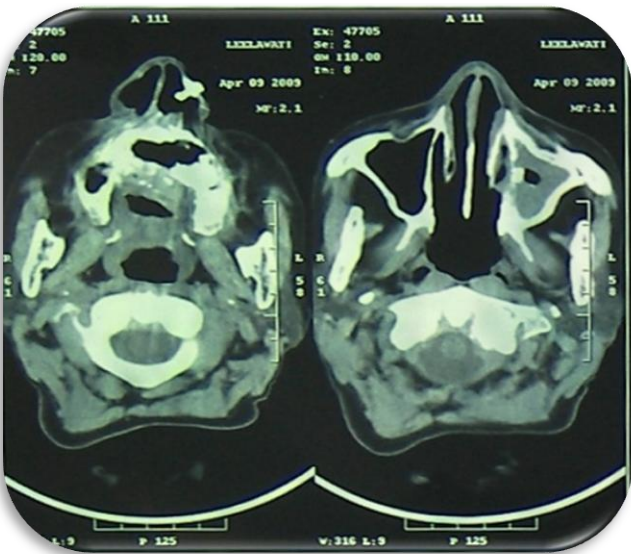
CT scan reveals destruction of upper alveolus, hard palate and walls of left maxillary antrum and thickening of sinus lining on left side of scan and destruction of palatal bone on right side.
